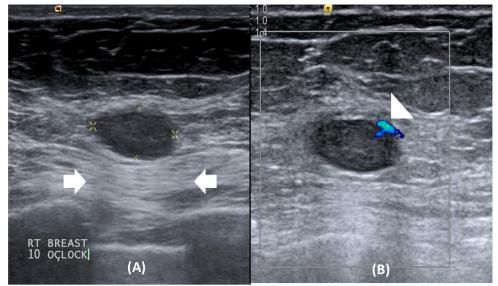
(A) Axial view and (B) Colour Doppler - example of false-negative case. A 61 years old lady with an underlying history of right renal cell carcinoma, presented with right breast 10 o'clock lesion (BIRADS 3) which showed well defined, homogenous, hypoechoic lesion with edge shadowing (arrow), but with internal vascularity (arrowhead) HPE finding was metastatic lesion from renal cell carcinoma.
